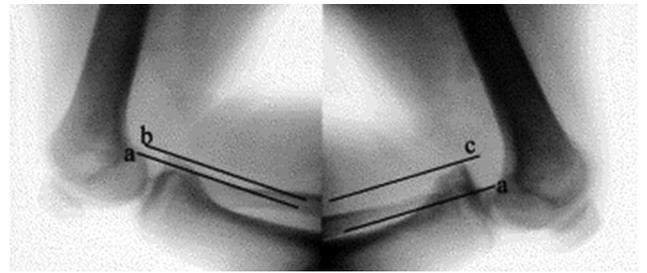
Stress radiographs of the lateral knee allow quantification of absolute posterior tibial displacement. Posterior displacement in excess of 8 mm indicates complete insufficiency of the posterior cruciate ligament (PCL). Greater than 10 mm of posterior tibial translation on stress radiography correlates with a combined posterolateral corner and PCL disruption. (Reprinted with permission from Margheritini F, Mancini L, Mauro CS, Mariani PP. Stress radiography for quantifying posterior cruciate ligament deficiency. *Arthroscopy*. 2003;19(7):706-711. ©2003, Elsevier Ltd.)
